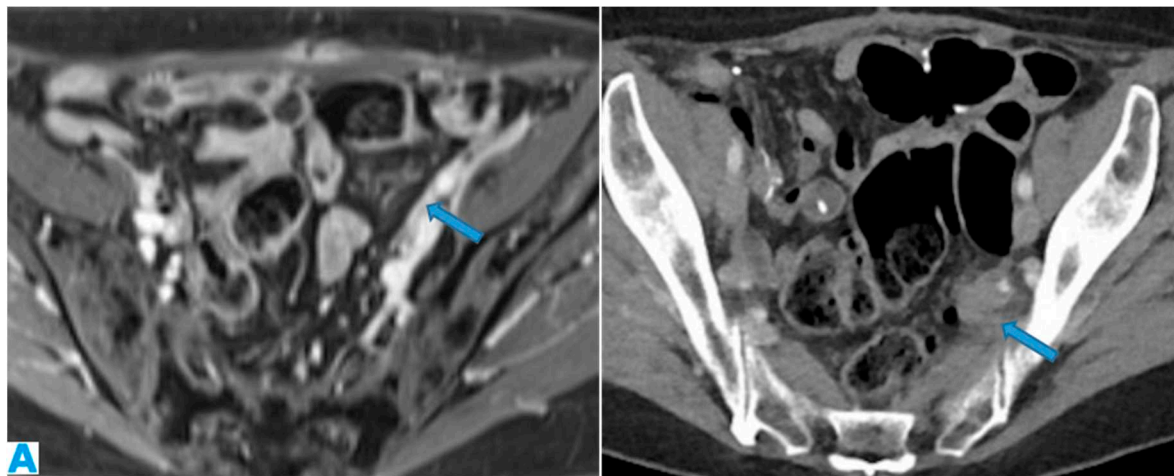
Axial CE portal phase FST1WI (A). PC from duodenal adenocarcinoma: Deposit seeding within the peritoneum that covers the left pelvic wall, which looks diffusely thickened (arrow). Axial CE-CT (B). PC from undifferentiated caecal adenocarcinoma: Nodular deposit within the peritoneum that covers the left pelvic wall (arrow).
